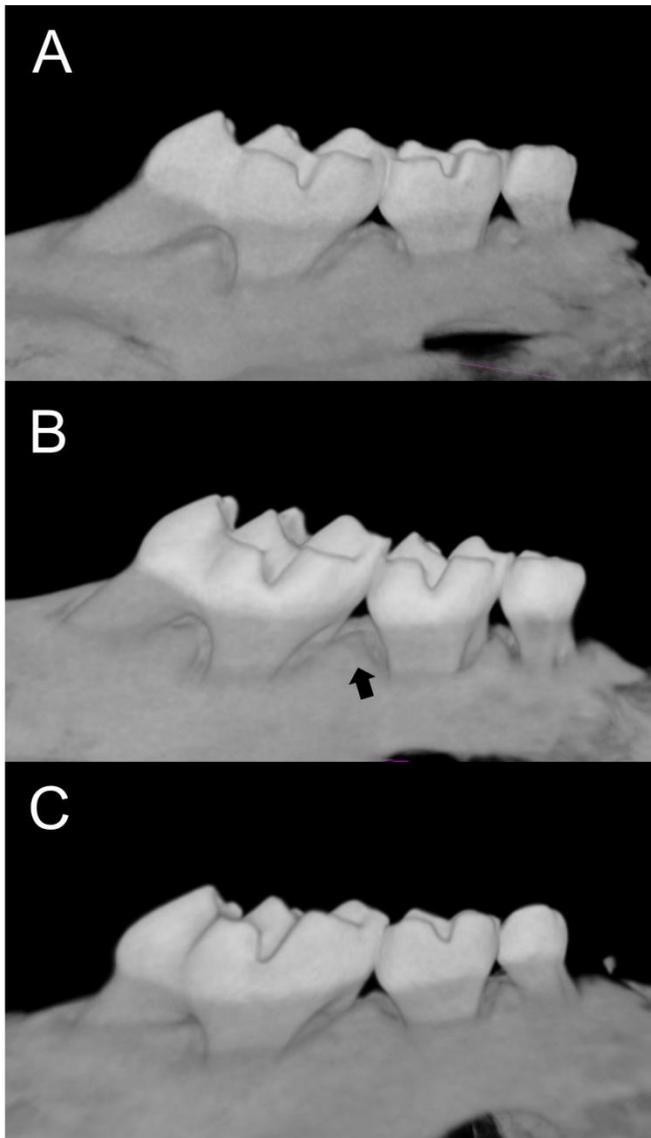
Three dimensional micro CT images at 7 weeks after infection.
